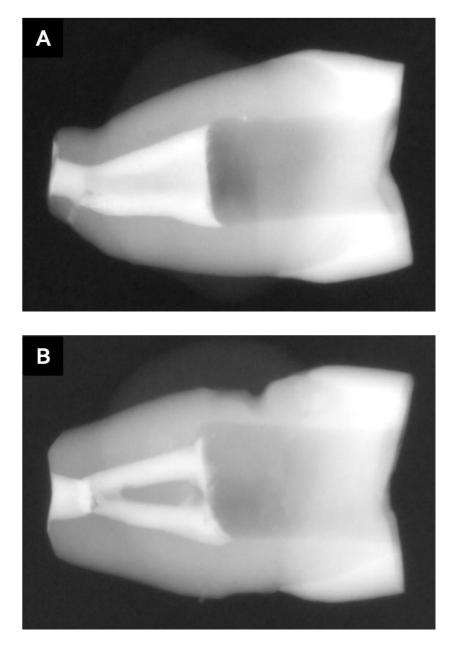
Representative periapical X-ray images
